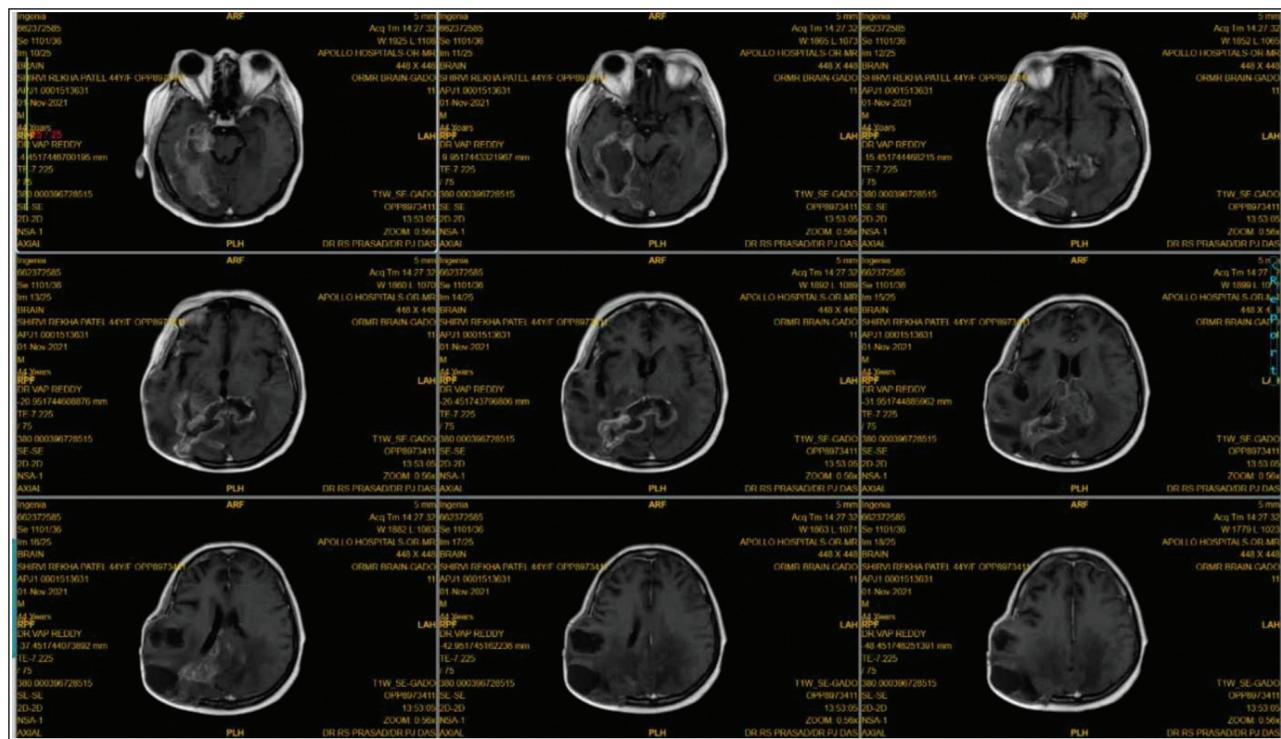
MRI T1 with contrast axial images at the time of recurrence
